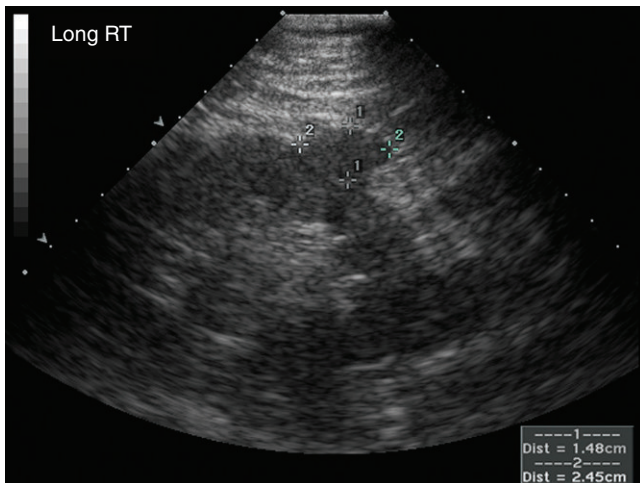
Follow-up ultrasound in three months demonstrates the mass (calipers), which appears exophytic and isoechoic to the rest of the parenchyma.
